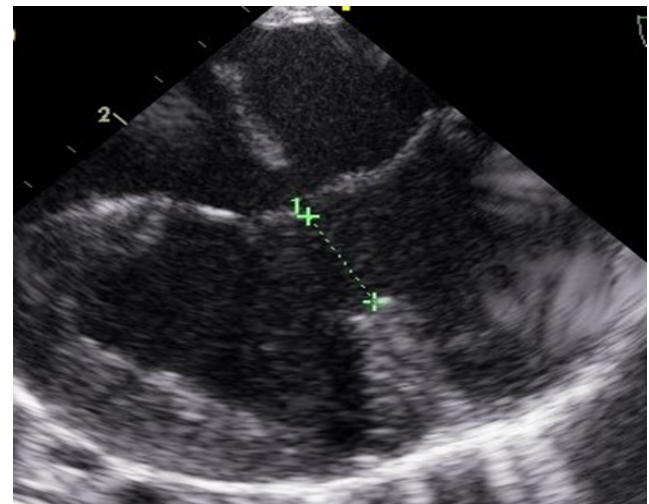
Transesophageal echocardiogram of twin 1 showing 0.5 cm Ostium Primum ASD, two 0.3 cm Ostium Secundum ASD's, 1 cm Inlet VSD (dotted line) and single AV valve.
